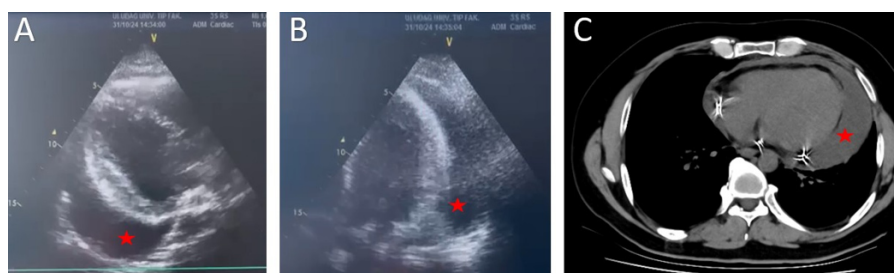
Transthoracic Echocardiography and Thoracic CT Images (A) Pericardial effusion reaching 3.6 cm at its thickest point in the parasternal long axis section. (B) Pericardial effusion appearance in the apical four-chamber section. (C) Pericardial effusion reaching up to 5 cm at its thickest point in the axial section of the thoracic CT scan. The red star indicates pericardial fluid.
